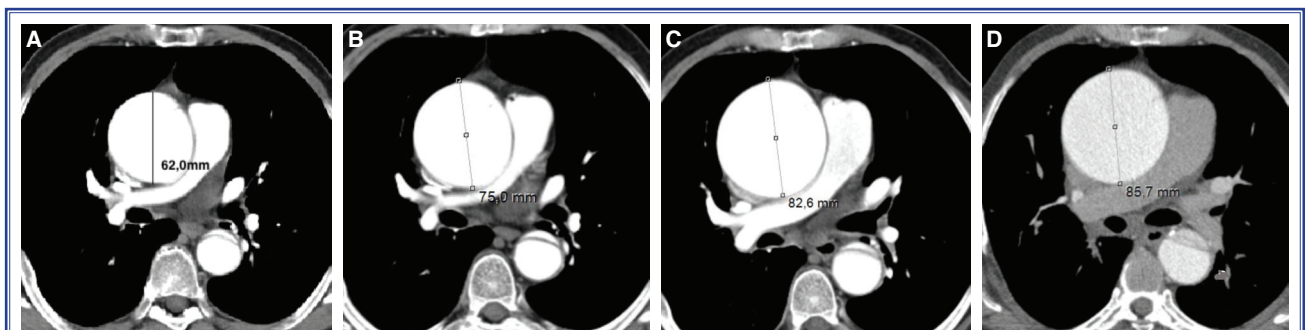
Contrast-enhanced computed tomography-based comparison of ascending aorta diameter in 2010 (A), 2013 (B), 2014 (C), and 2016 (D).
